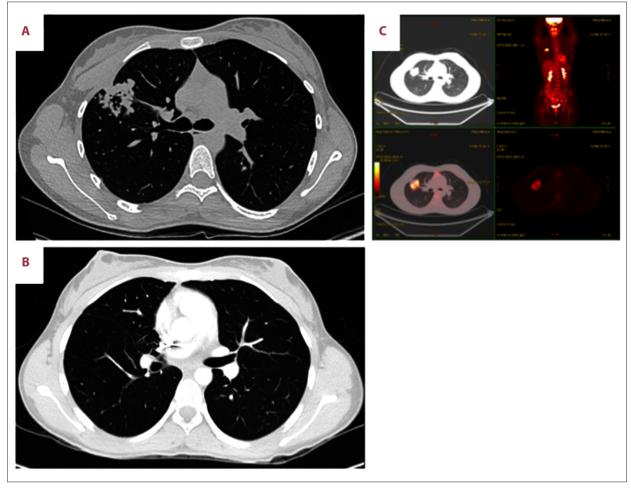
Computed tomography (CT) scan at diagnosis and positron emission tomography and CT-scan (PET/CT) at diagnosis, before surgery (A, B). CT scan after surgery at last follow-up visit (C).
